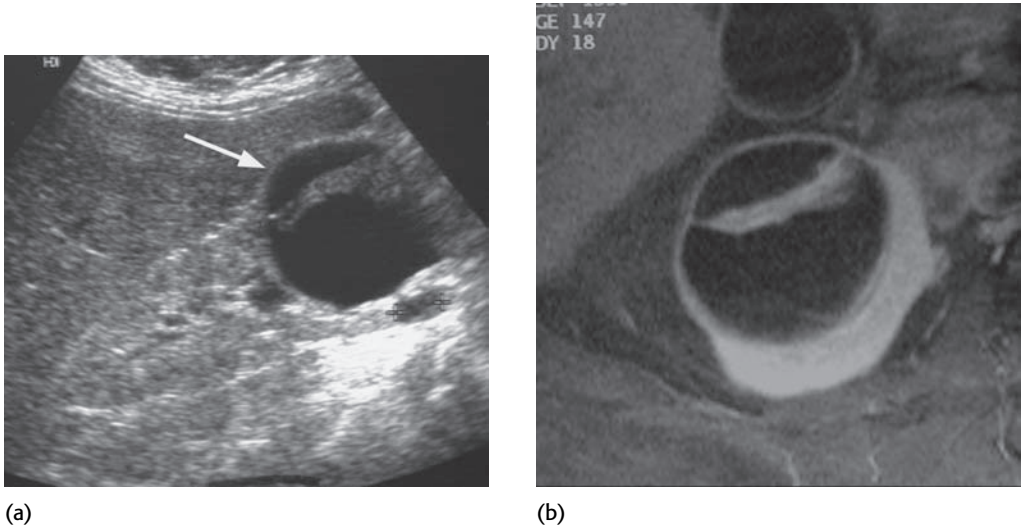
MRI diagnosis of a Category III cyst. An ultrasound examination (a) shows a mass (arrow) containing thick lobulated internal septations. The same feature is well visualized on an axial fat-saturated gadolinium-enhanced T1-weighted image (b).
